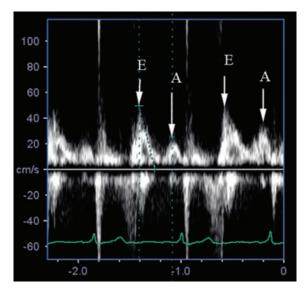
Tricuspid pulsed-wave Doppler inflow demonstrates both an early diastolic E-wave and a late diastolic A-wave.
